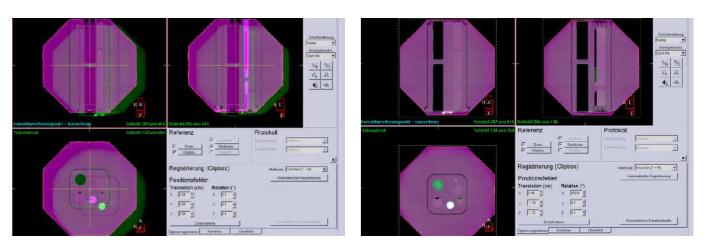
CBCT image registration of RUBY with the System QA insert. Left: Before image registration. Right: After Image registration
